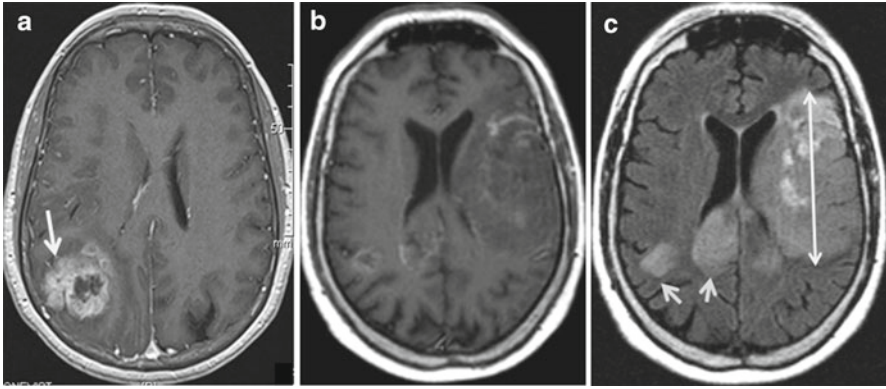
Brain tumors and blood–brain barrier function. (a) Contrast enhancement of glioblastoma (*arrow*). The blood–tumor barrier is often porous in malignant brain tumors and this is demonstrated by the transvascular extravasation of the contrast agent that produces the contrast-enhancement effect on MRI study (T_1 weighted image with Gadolinium). (b) A MRI image of glioblastoma that demonstrates a mass effect on the left lateral ventricle with scanty areas of contrast enhancement (T_1 weighted image with Gadolinium). (c) The fluid attenuation inversion recovery (FLAIR) sequence of the MRI study of the tumor shown in (b). It demonstrates a large and extensive tumor (observed as hyperintensity) that involves the left hemisphere and produces the mass effect on the left lateral ventricle (the *double head arrow* delineates the longest diameter of the left hemispheric tumor). The tumor also crosses the splenium of the corpus callosum and involves the posterior aspect of the right hemisphere (*arrows*). Judged by the extent of the tumor on this FLAIR sequence most of the tumor mass is located behind an intact physiological barrier (no extravasation of the injected contrast agent on (b))
